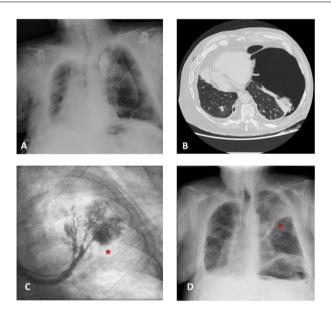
(A) Portable chest radiograph showing left pneumothorax. (B) Chest computed tomography confirming persistent pneumothorax. (C) Fluoroscopic image demonstrating a bronchopleural fistula (*). (D) Posteroanterior chest radiograph showing resolution of persistent left pneumothorax.
